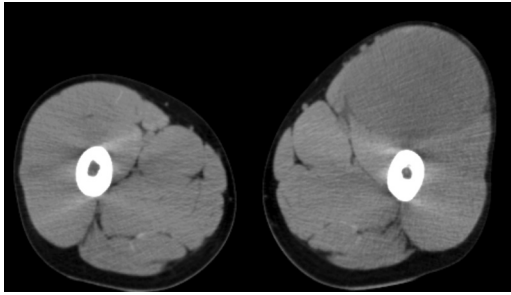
Axial slice of CT scan: A tumor in the left thigh.
